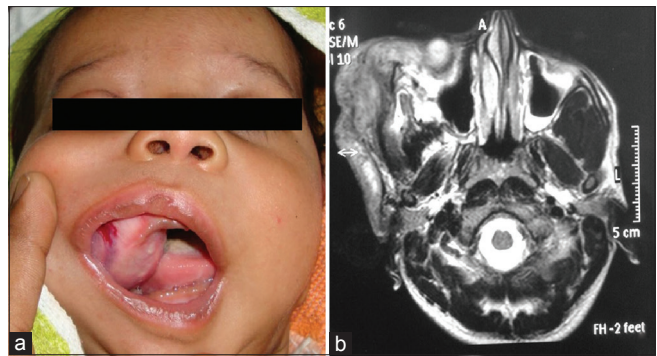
(a) A 10 cm × 5 cm × 5 cm nontender, firm swelling in the right side of face involving the zygomatic and maxillary region. Intraorally, the mass is seen bulging from the roof of oral cavity. (b) Magnetic resonance imaging shows an ill-defined T2 hyperintense mass lesion in the right cheek soft tissues, involving the zygomatic arch of maxilla and extending toward floor of orbit
